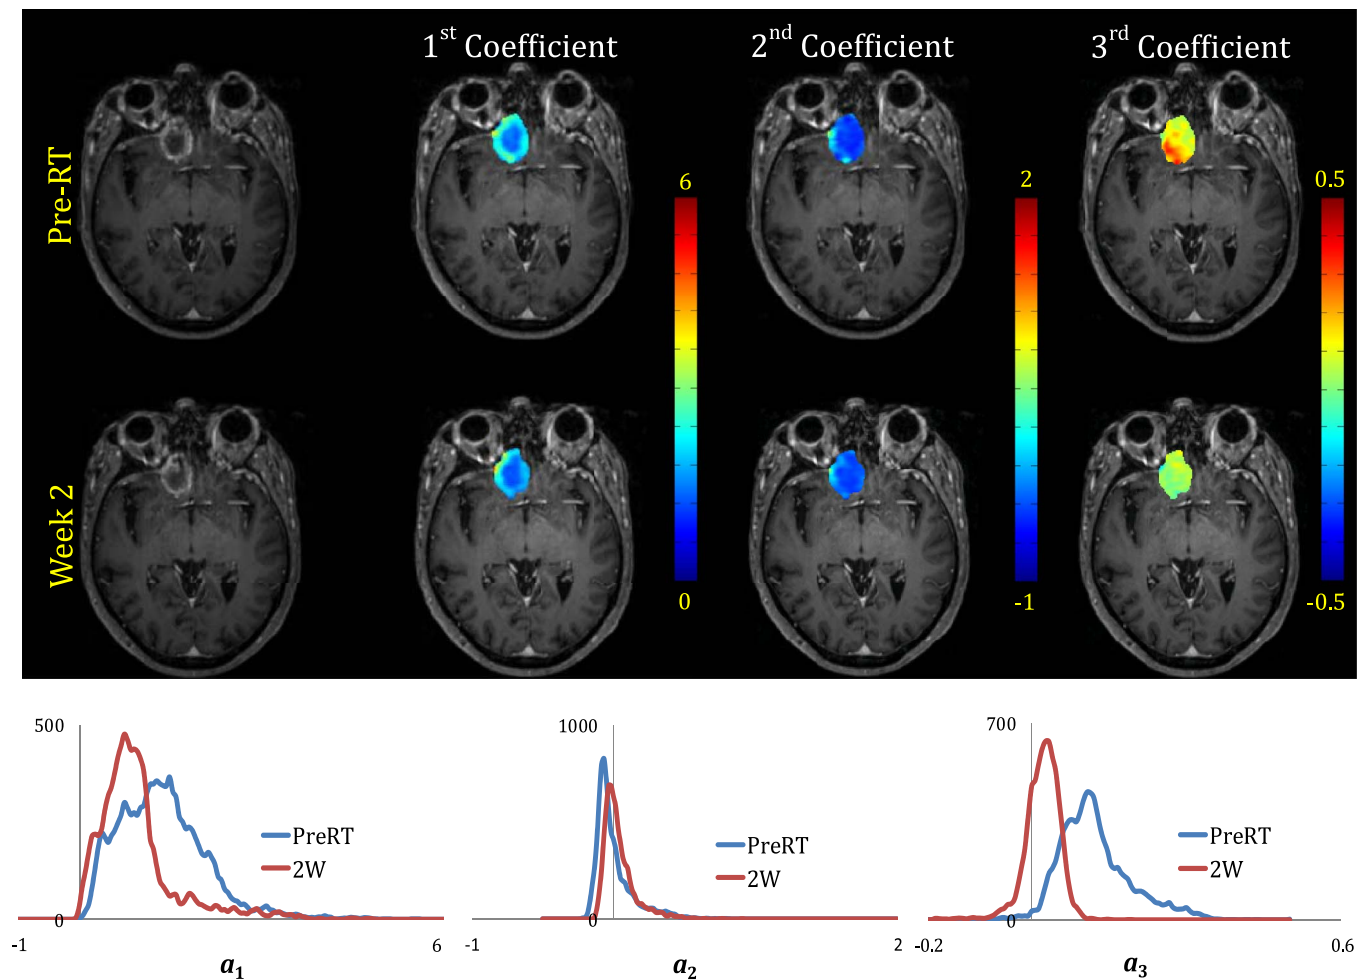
Distribution patterns and histograms of the first three projection coefficient maps for a responsive brain metastasis (from patient #19) overlaid on T1-weighted images at pre-RT and week 2 after start of whole brain radiation therapy.
